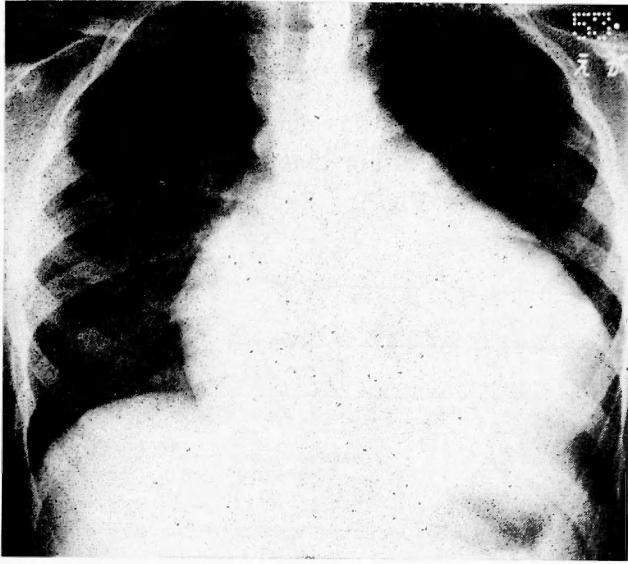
Chest x-ray film of the case 2.
